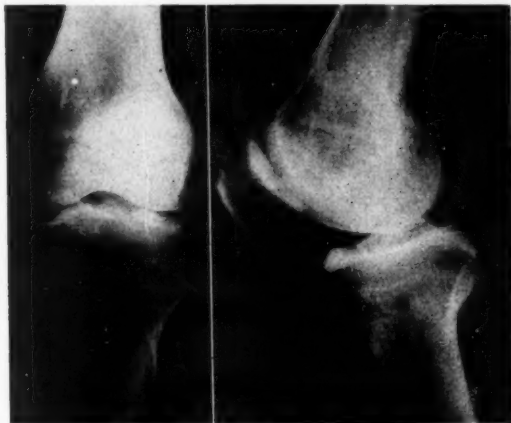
(Left). Antero-posterior radiograph of knee showing free body lying close to tibia in lateral side of joint. This body is beneath the lateral meniscus.
